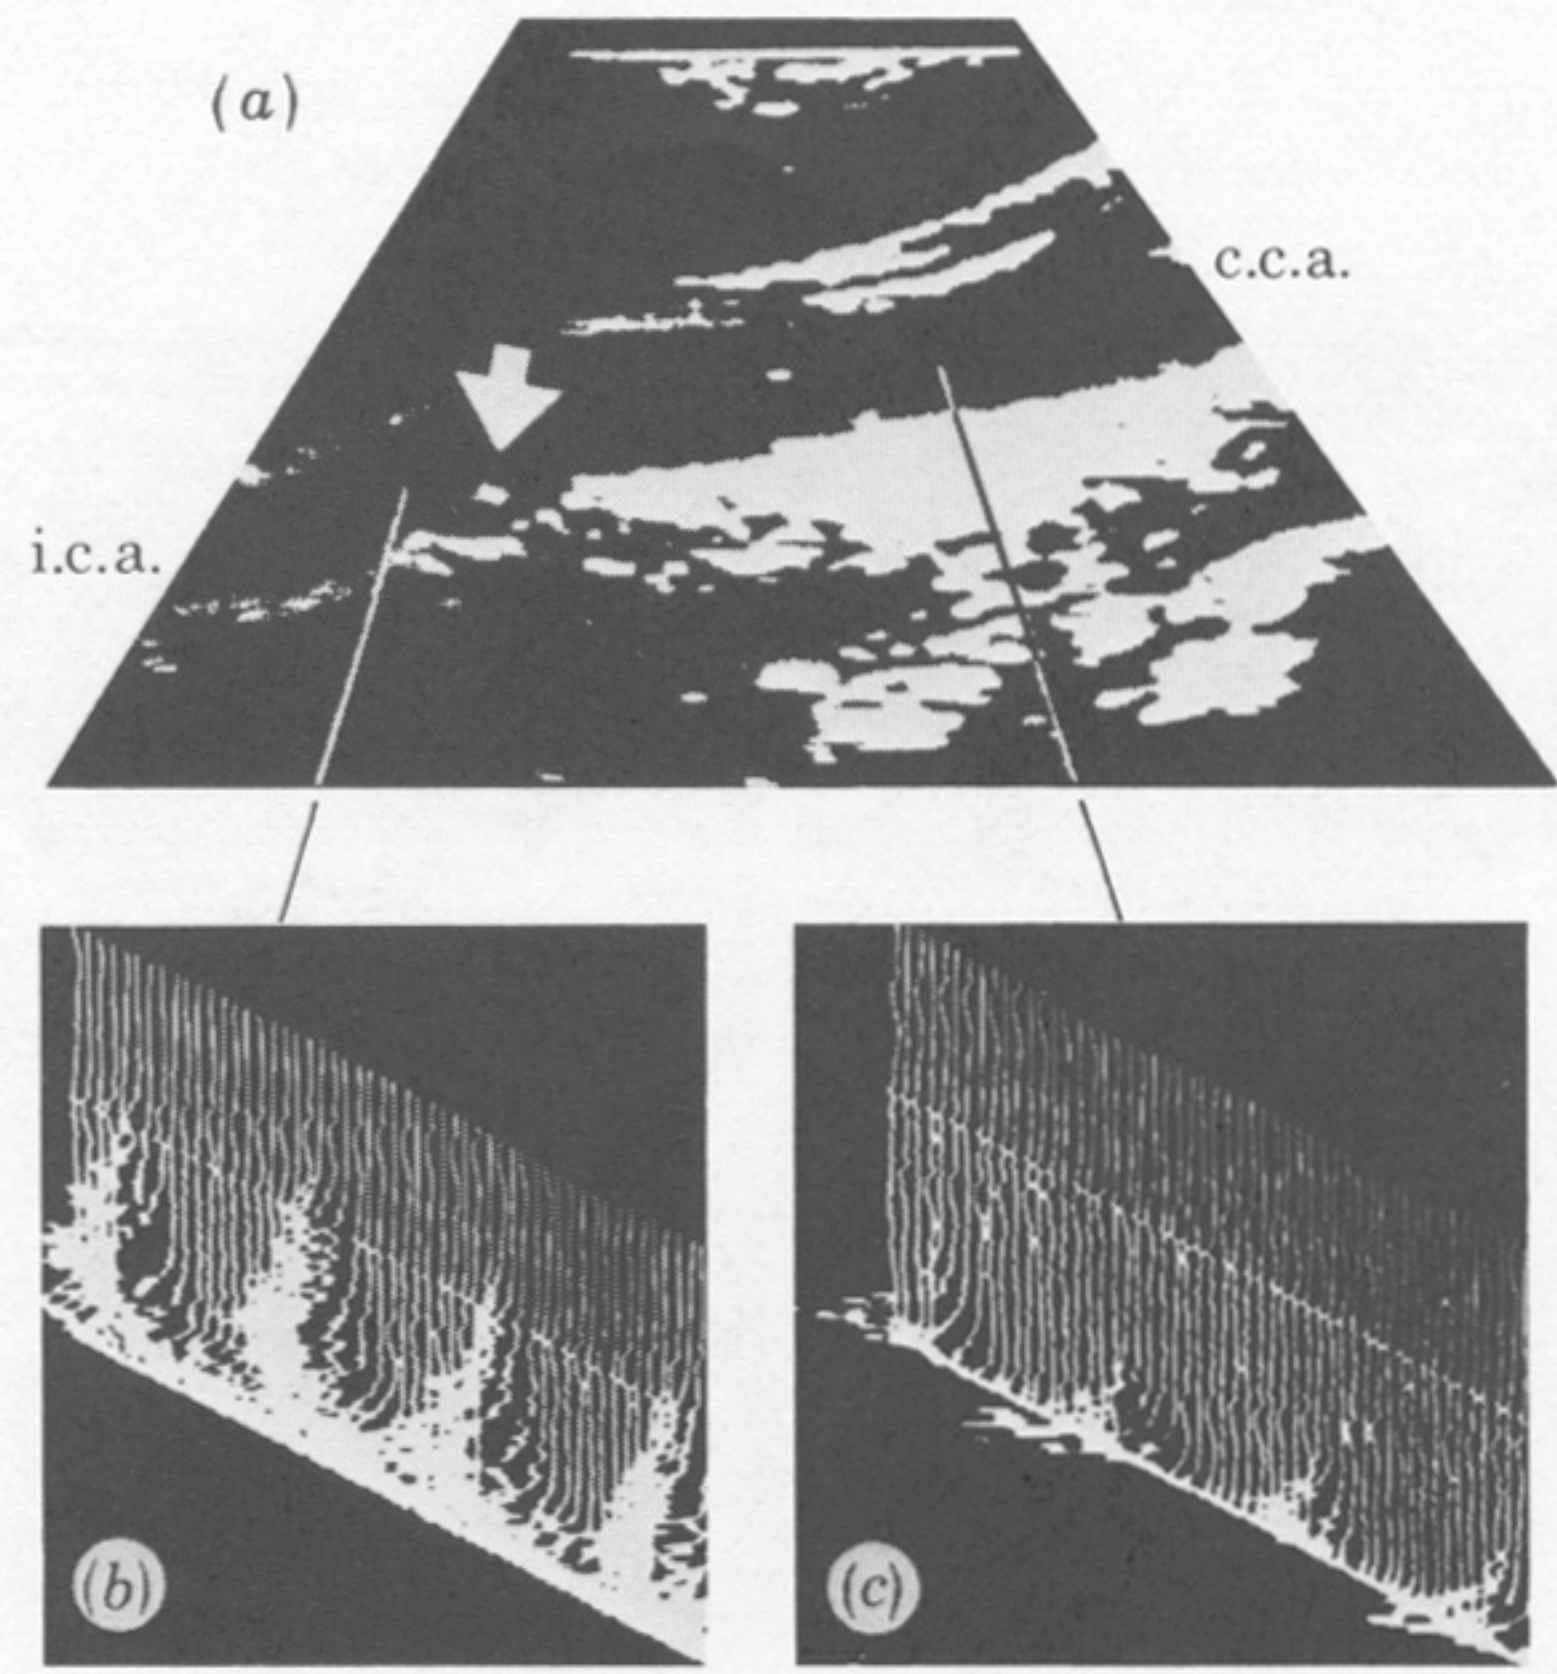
Duplex scan (a) of carotid artery, and Doppler velocity spectral analysis distal (b) and proximal (c) to a small lesion in the carotid bulb. There is a turbulent pattern with increased velocity just distal to the lesion.
